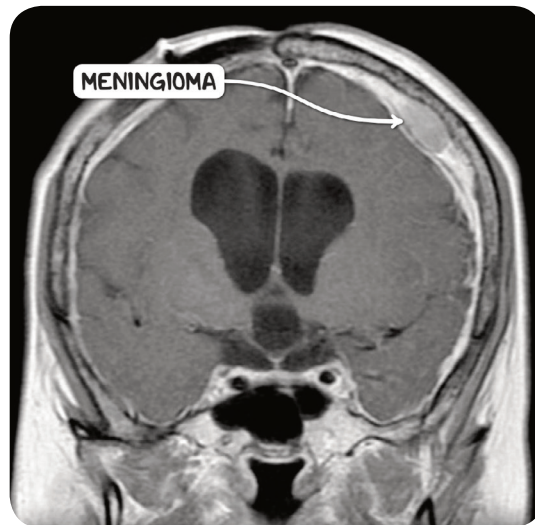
An MRI scan of the head in the coronal plane demonstrating a meningioma.
